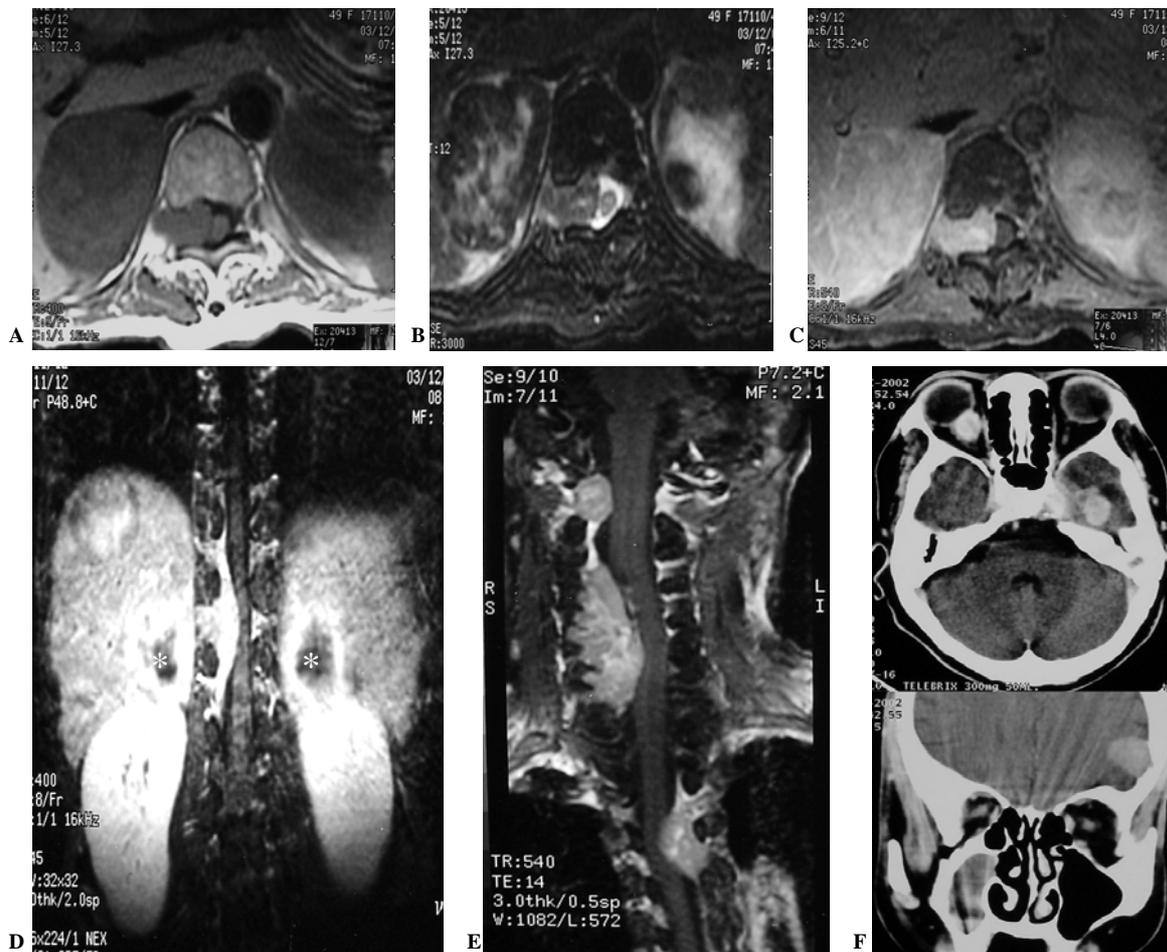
Case III : A 40-year-old female presented with right hemiparesis. Axial image reveals a lobulated lesion expanding right neural foramen. This lesion shows inhomogeneous isosignal intensity to the spinal cord on T1-weighted image (A), slightly high signal intensity on T2-weighted (B) and heterogeneous enhancement after injection of contrast material (C). Post contrast coronal T1-weighted images at level of cervical (E) and thoracolumbar (D) spines demonstrate multilevel involvement at C1-C7, T12-L1 on the right side and T2 on the left side. Accidental findings of heterogeneous enhancing lesions at the bilateral suprarenal regions (*) and dome of the liver are noted. Post contrast axial and coronal CT images of the brain show two enhancing lesions in the left temporal lobe and left frontal lobe. The lesion in the left frontal lobe abuts the inner table of the left frontal bone which shows bony destruction. The other oval-shaped dense enhancing mass is also seen at the retrobulbar area
